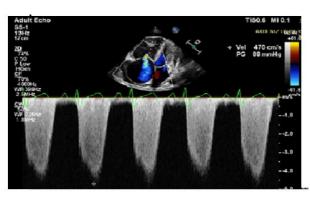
Comparative view with second echocardiography: moderate tricuspid regurgitation and PAB; calculated over maximum TY velocity; following drug discontinuation and clinical improvement.
